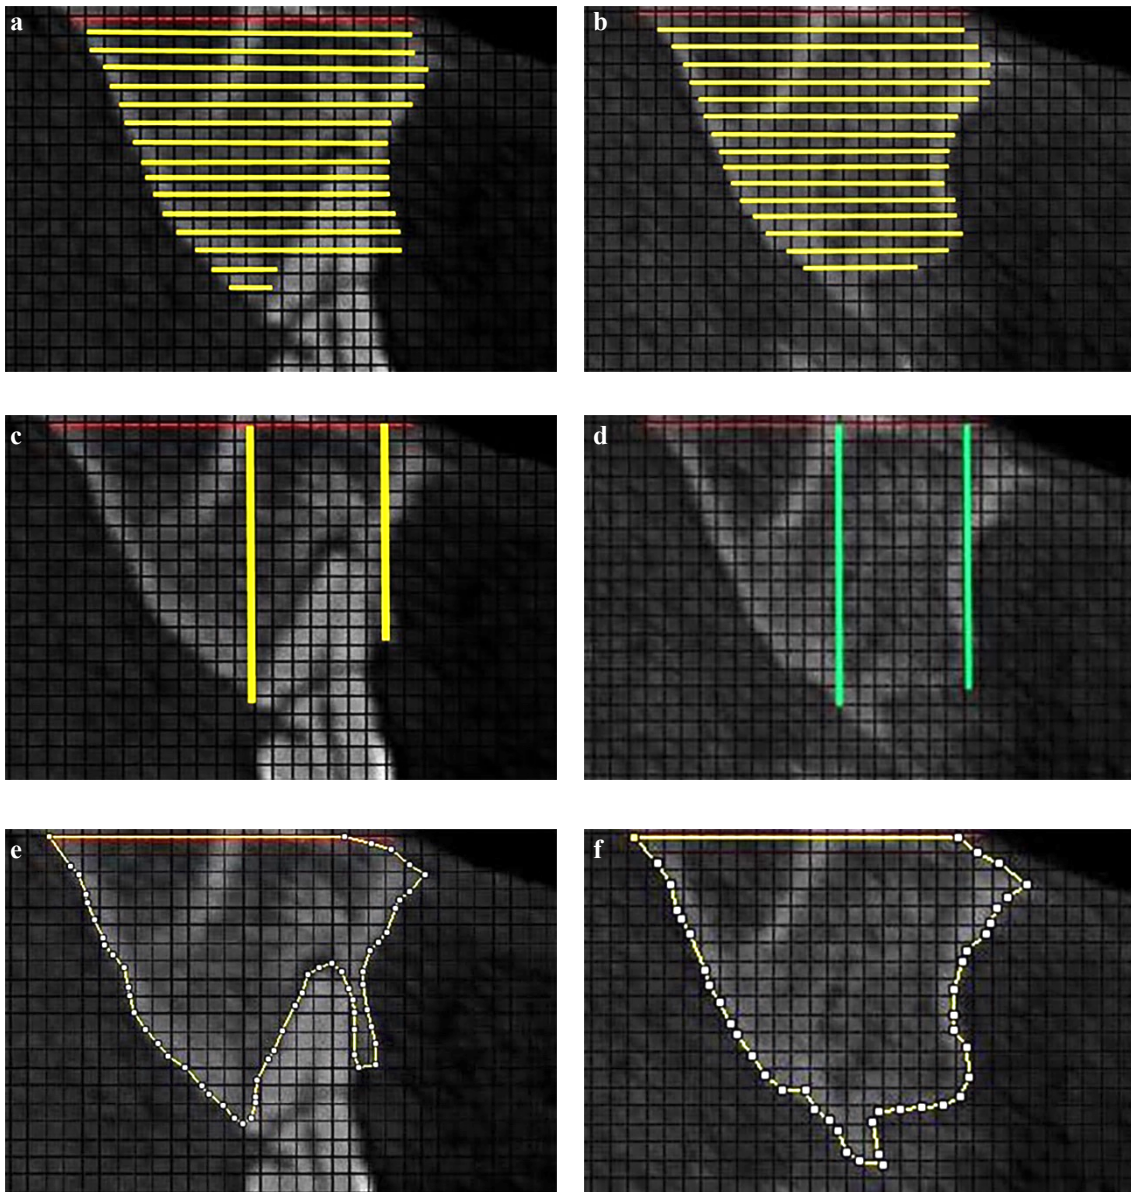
Radiographic evaluation protocol, hard tissue dimension changes in a test patient
